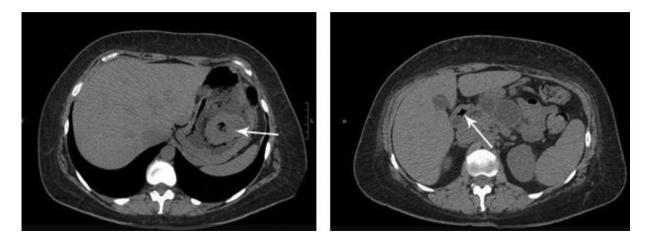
CT Abdomen w/o contrast showing Gastric body mass with central ulceration (left image, white arrow) and cystic dilation in pancreas (right image, white arrow)
